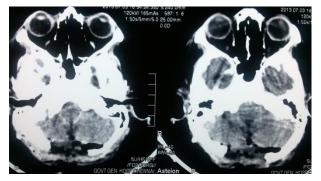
CT BRAIN PLAIN SHOWING HYPERDENSE LESION IN THE MIDLINE COMPRESSING THE FOURTH VENTRICLE WITH OBSTRUCTIVE HYDROCEPHALUS
